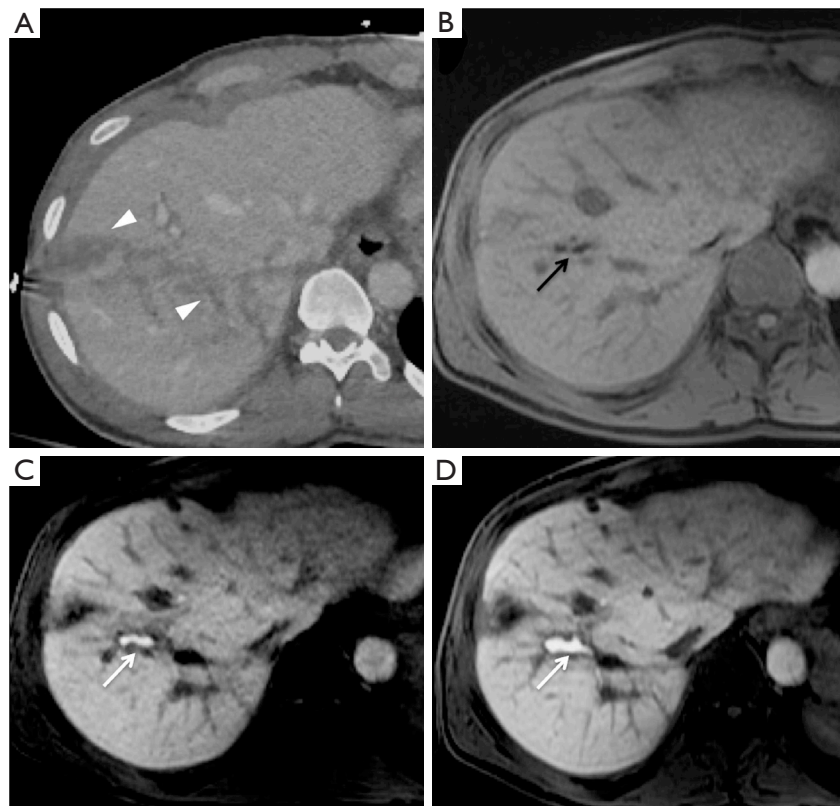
Example of intra-hepatic biliary leak after abdominal trauma. Biliary leak within liver laceration in a 43-year-old man referred to an ED after abdominal trauma due to a motor-vehicle accident. Portal phase at admission CT scan (A) show large VII–VIII segment liver laceration (white arrowheads); T1-weighted fat-saturated axial MRI scan acquired before contrast media administration (B) showed the absence of spontaneous T1 hyperintensities due to blood products in the selected MRI slice (black arrow); subsequent T1-weighted fat-saturated axial MRI scan at the same level acquired at 10 (C) and 35 (D) minutes after gadoxetate disodium administration showed a biliary leak within the liver laceration, with a collection slightly increasing in diameter over time (white arrows). ED, emergency department; CT, computed tomography; MRI, magnetic resonance imaging.
